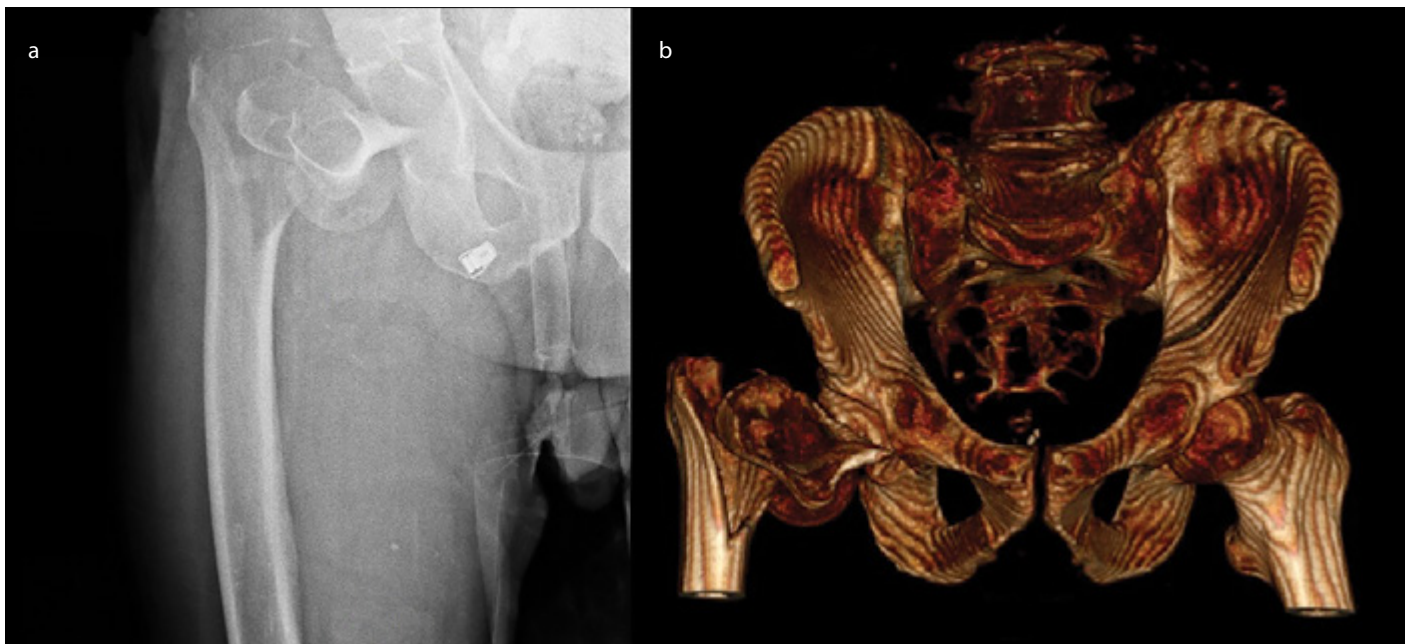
a, b. X-ray image of the right hip (a), 3D Computed tomographic image of the pelvis (b)
